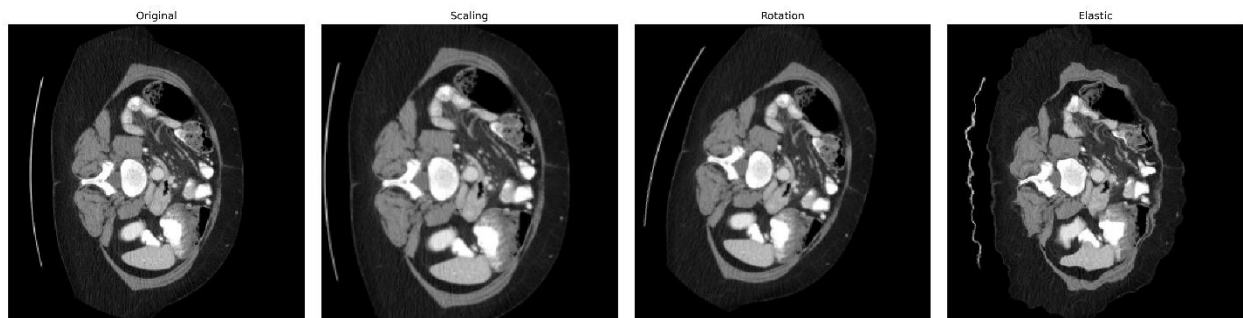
CT colon data Augmentation with scaling, rotation, and elastic deformation.
